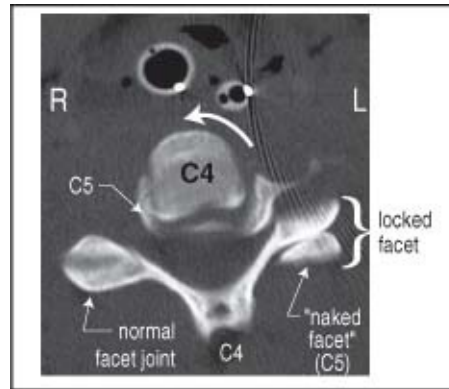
Locked facet (left C4-5). (CT scan). Note the rotation of the C4 vertebral body on C5 (curved arrow)
